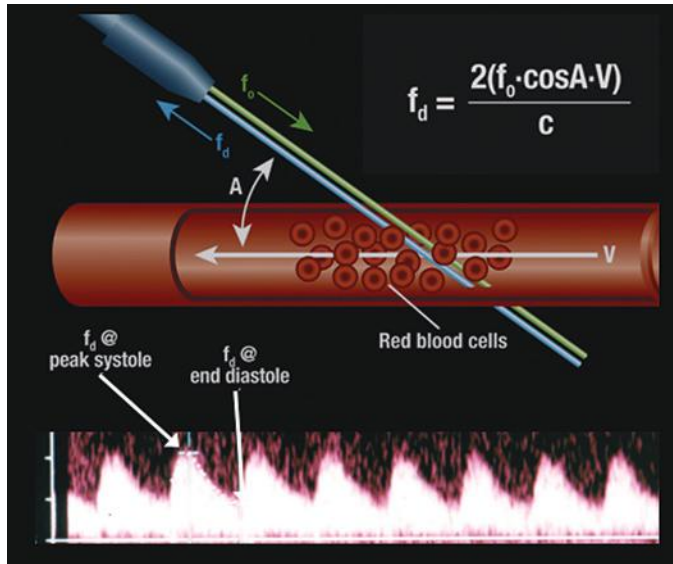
The Doppler effect (f_d) is dependent on the initial frequency of the ultrasound transducer (f_0), the velocity of flow (V) of the blood within a vessel, and the cosine of the angle (A) that the ultrasound beam makes with the direction of blood flow. The frequency shift (f_d) is displayed as a time-dependent plot within a cardiac cycle and is inversely proportional to the constant (c), which reflects a constant related to the medium in which the sound is traversing.
